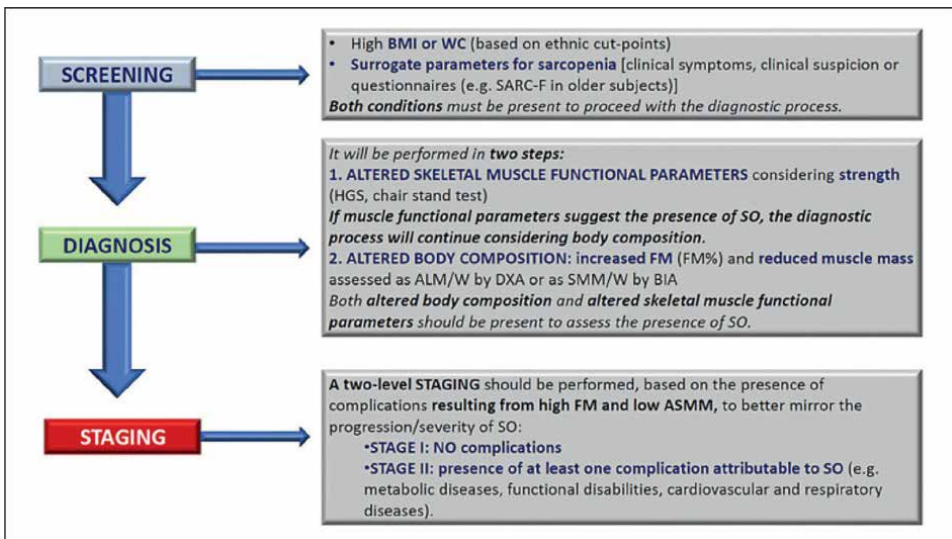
Diagnostic procedure for sarcopenic obesity. ALM/W, appendicular lean mass adjusted to body weight; ASMM, absolute skeletal muscle mass; BIA, bioelectrical impedance analysis; BMI, body mass index; DXA, dual X-ray absorptiometry; FM, fat mass; HGS, hand-grip strength; SMM/W, total skeletal muscle mass adjusted by weight; SO, sarcopenic obesity; WC, waist circumference; SARC-F, strength, assistance with walking, rising from a chair, climbing stairs and falls. Note. This figure was produced by previous article. From Ref. [6]. Reprint with permission from Elsevier.
